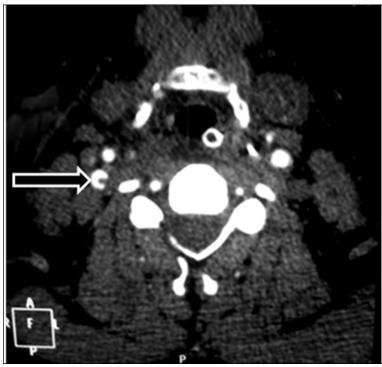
Initial CT angiography (MIP in axial plane) of the neck arteries shows partial thrombosis of right ICA (arrow)
